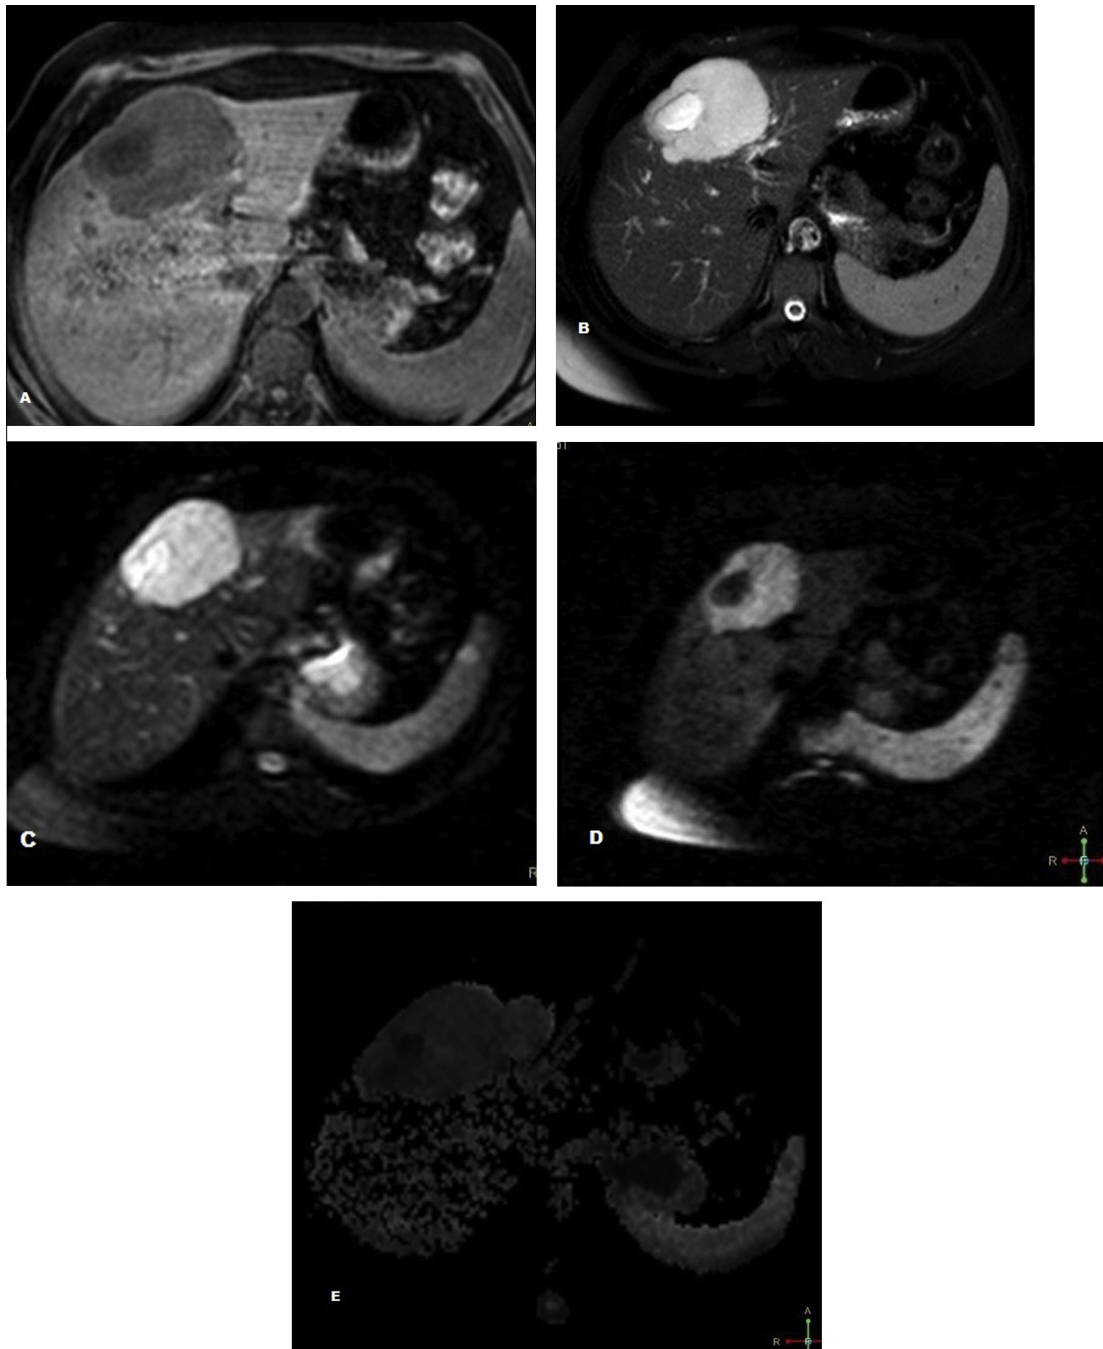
MR imaging of hemangioma in a 41 years old patient. (A) Axial T1GE shows well defined hypointense lesion with central area of marked hypointensity in segments IV and VIII. (B) Axial T2WI reveals hyperintensity of the lesion with area of marked hyperintensity. (C) Diffusion weighted echo planar image with $b = 0$ shows marked homogenous hyperintense lesion. (D) Diffusion weighted echo planar image with $b = 1000$ shows hyperintense signal with central hypointense area. (E) ADC map of the lesion reveals isointense lesion with central area of hypointensity. The lesion has high ADC value of $1.9 \times 10^{-3} \text{ mm}^2/\text{s}$ suggestive of benign lesion.
